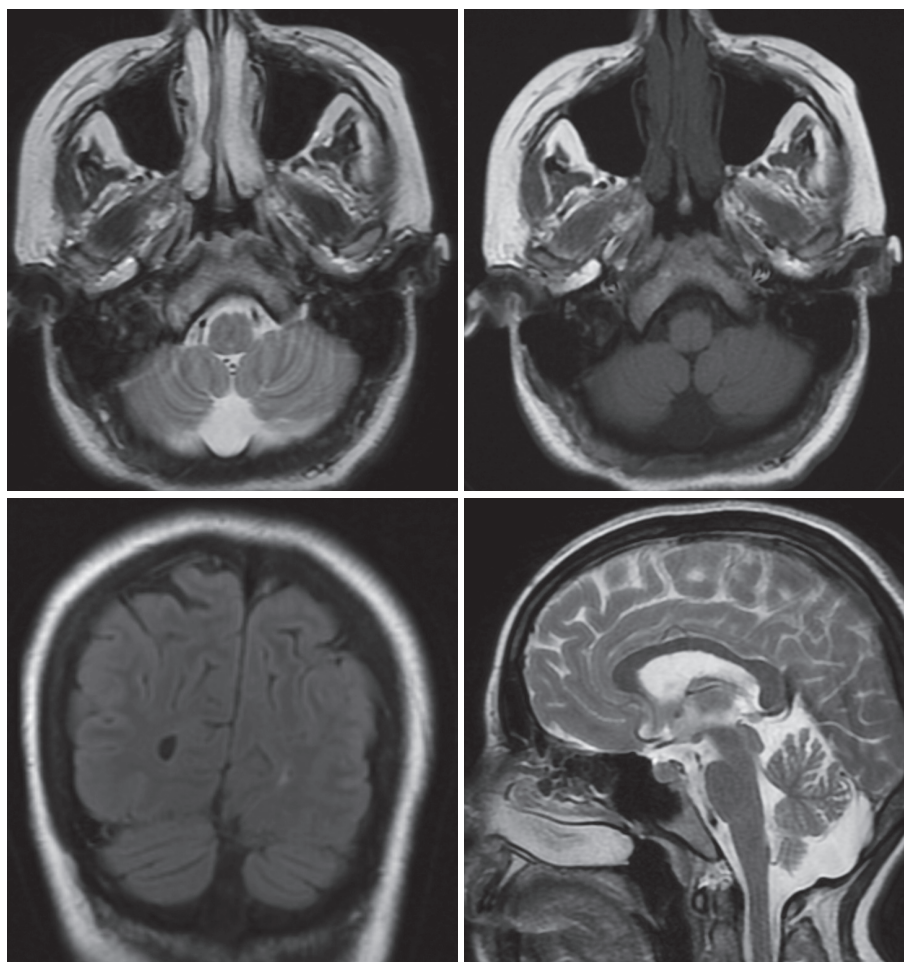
Magnetic resonance images of the case demonstrates Dandy walker variant.
